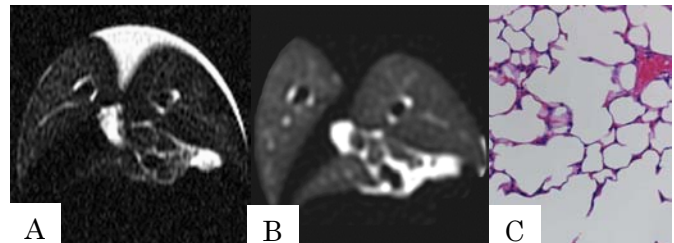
Control lung A) SE image, B) corresponding CT, C) microphotograph (H-E).
